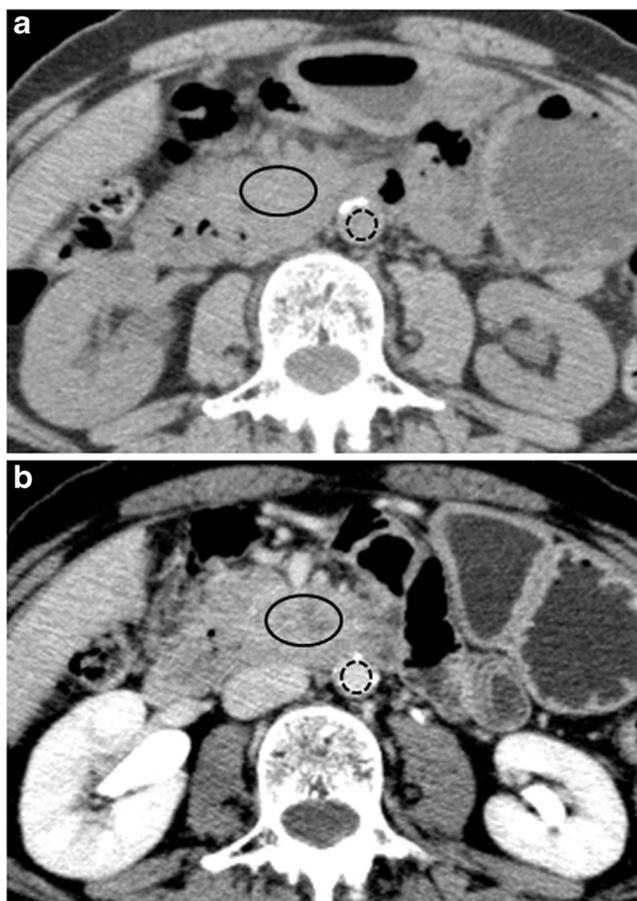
A 68-year-old woman with pancreatic adenocarcinoma (TNM stage IV) who survived for 21.9 months after chemotherapy. Axial unenhanced (a) and equilibrium phase contrast-enhanced CT (b) show regions of interest placed on a tumour measuring 36 mm in diameter (black circles) in the pancreas head and the aorta (black dotted circles). Tumour contrast enhancement and extracellular volume fraction were 61.8 HU and 38.8%, respectively
